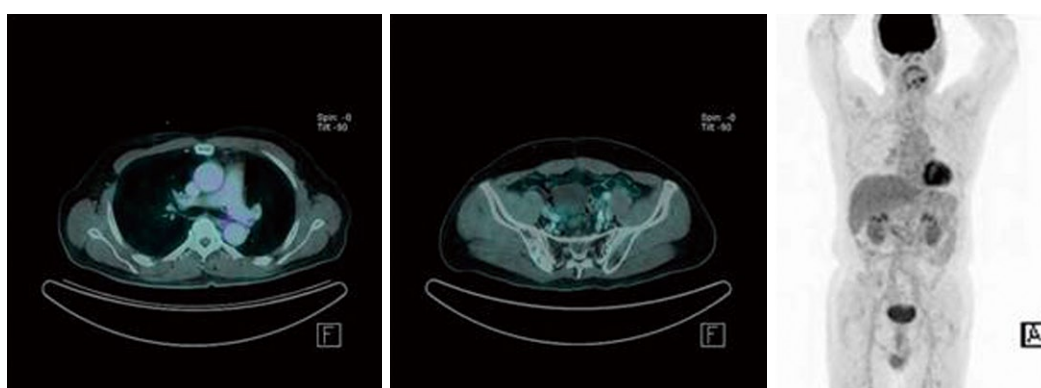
Recent whole body positron emission tomography computed tomography showing no evidence of hypermetabolic lesions 25 mo after surgical resection.
